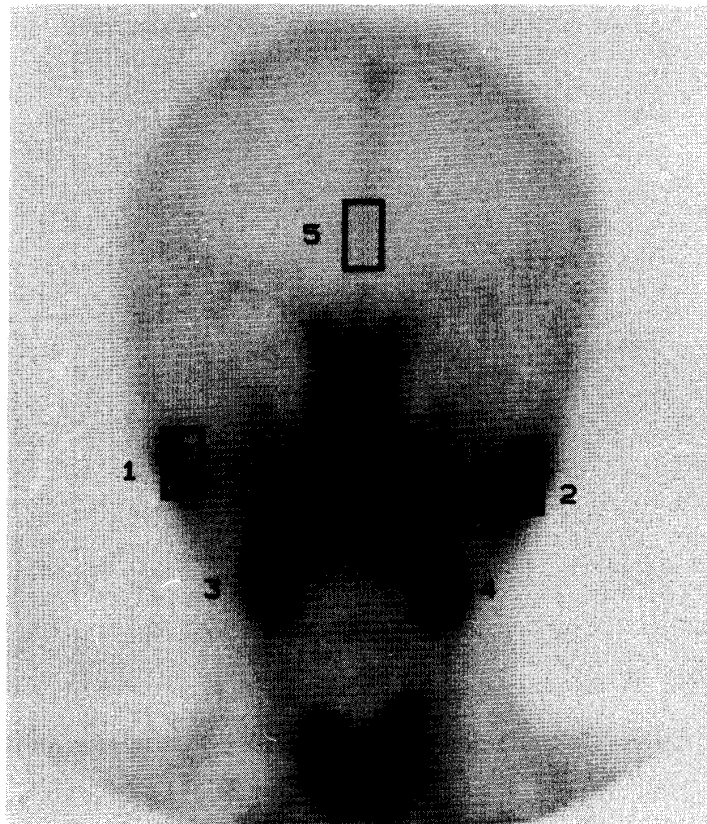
ROIs of Salivary Glands of Sequential Sialoscintigraphy
